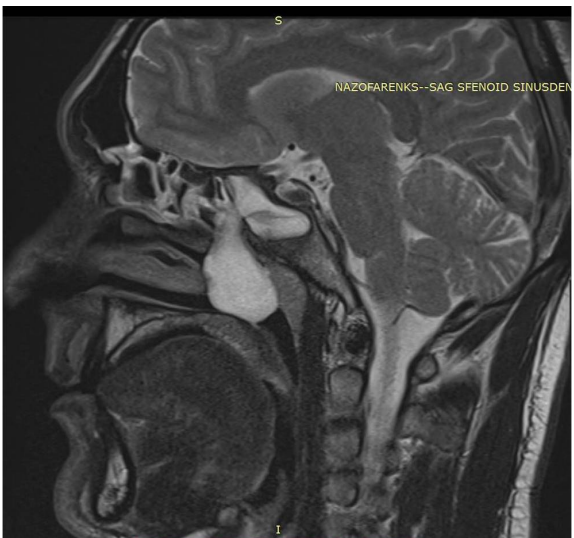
Preoperative sagittal magnetic resonance imaging showing a soft tissue mass extending from the right sphenoid sinus to the posterior nasal cavity and nasopharynx.
